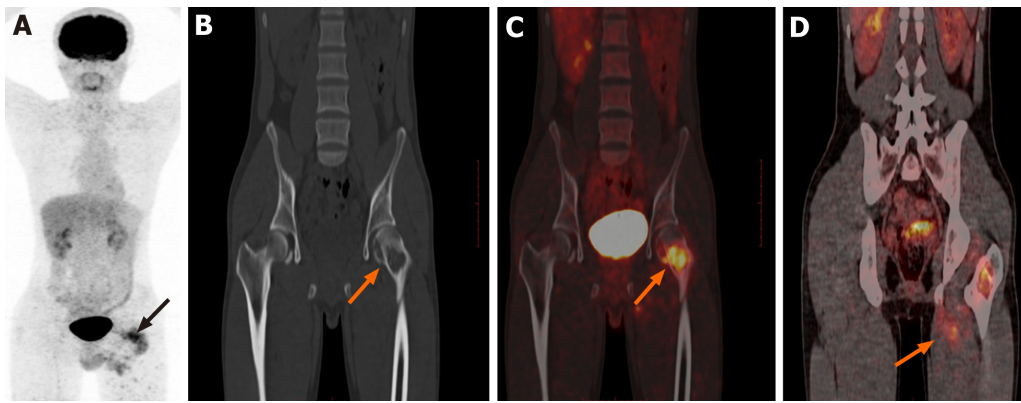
^{18}F -deoxyglucose positron emission tomography/computed tomography imaging. A: Positron emission tomography maximum density projection shows intense metabolic foci in the left femoral region; B-D: Computed tomography and positron emission tomography/computed tomography fusion images showing visible bone crest in the area of osteolytic lesions in the left femur, increased metabolism (maximum standardized uptake value: 4.2), and involvement of surrounding muscles.
